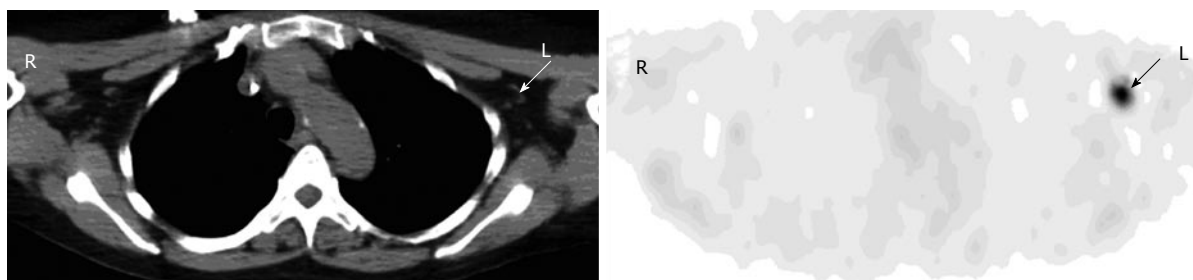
Axillary uptake. A 63-year-old man with history of bladder cancer had fluorodeoxyglucose (FDG) positron emission tomography-computer tomography (PET-CT) for restaging. Axial PET image of the upper chest shows focal uptake in the left axilla (arrow). Corresponding to this focus, there is a small benign lymph node with fat lumen on CT (arrow). The uptake is secondary to infiltration of injected FDG at the antecubital site.
